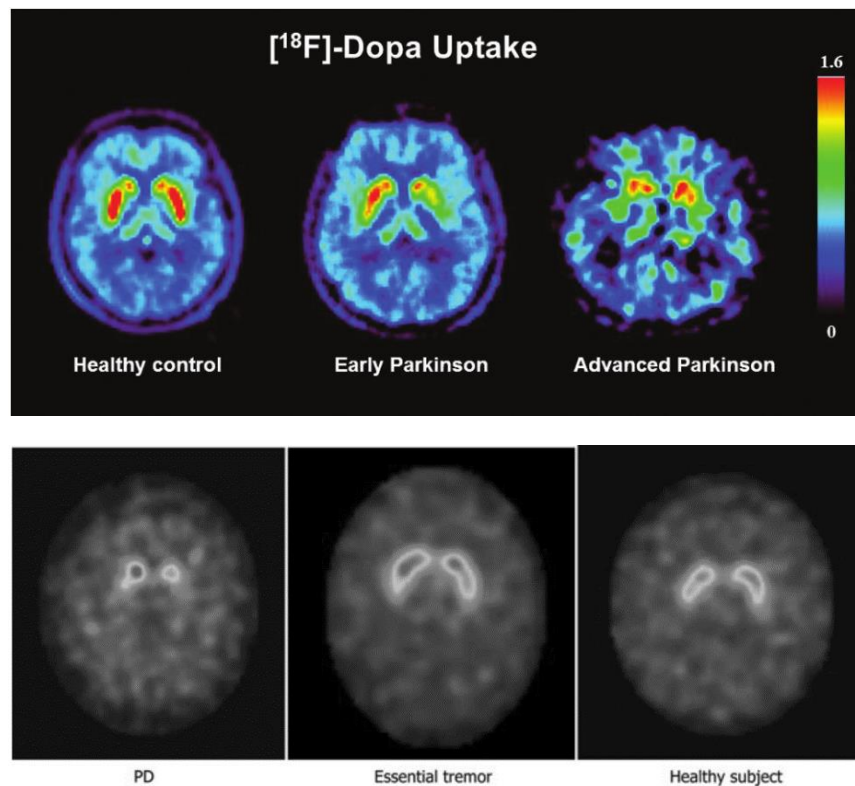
DaT-SPECT images from PD patients in various stages of the disease compared to healthy control (top) (Booth et al., 2015) and compared to an ET patient (bottom) (Berardelli et al., 2013)
